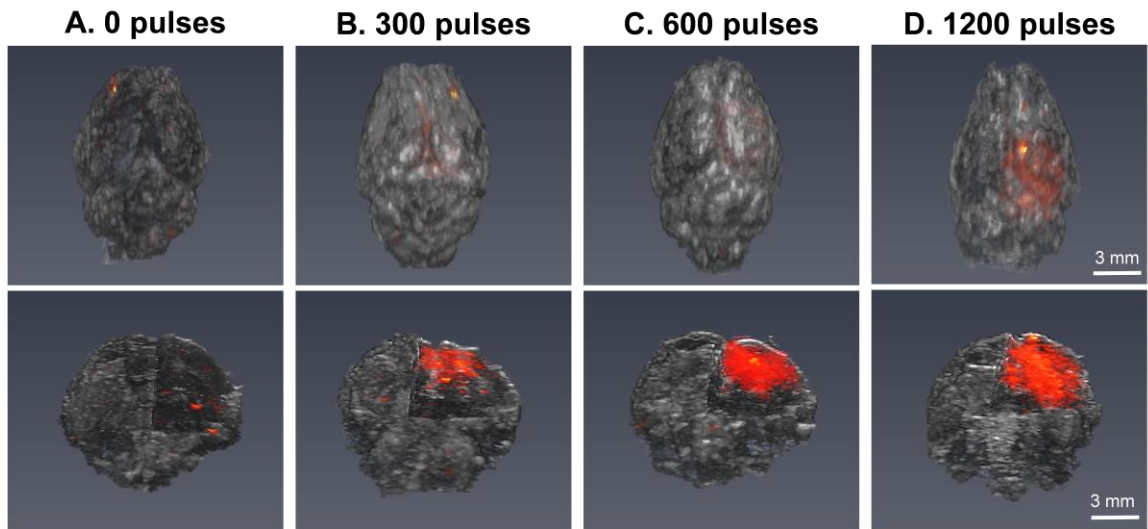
Reconstructed 3D top view and right side, corner cut images of ultrasound (US, grayscale) and photoacoustic (PA, hot colormap) data for varying number of laser pulses: (A) 0 pulses, (B) 300 pulses, (C) 600 pulses, and (D) 1200 pulses. Note: Laser pulse Figure 12A and Figure 12C use the same images as laser fluence Figure 13A and Figure 13C, and experiments shown in (B-D) were performed with a laser fluence of 56 mJ/cm². Reprinted from [112].
